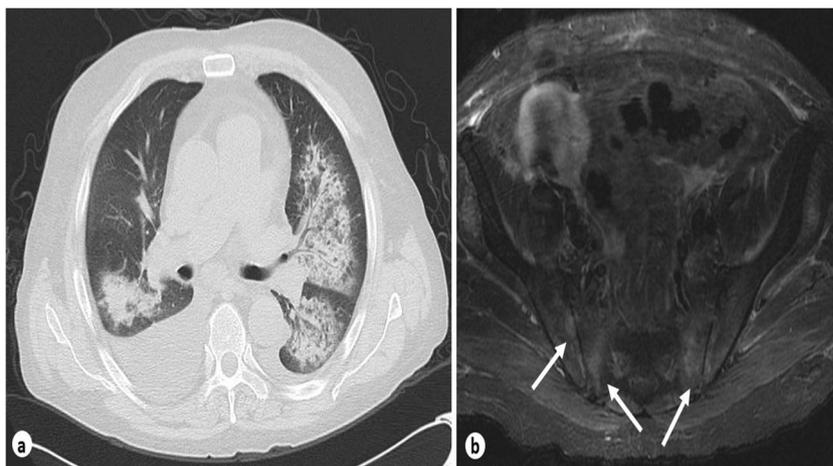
Patient 14. a Axial chest CT scan (lung window) with bilateral patchy infiltrates with air bronchogram and areas of ground glass opacities during an episode of diffuse alveolar hemorrhage. b Axial STIR sequence MRI at an axial plane of the sacroiliac joints shows high signal subchondral bone marrow edema (arrows) and small erosions in the iliac aspect of the right sacroiliac joint suggestive of bilateral sacroiliitis
